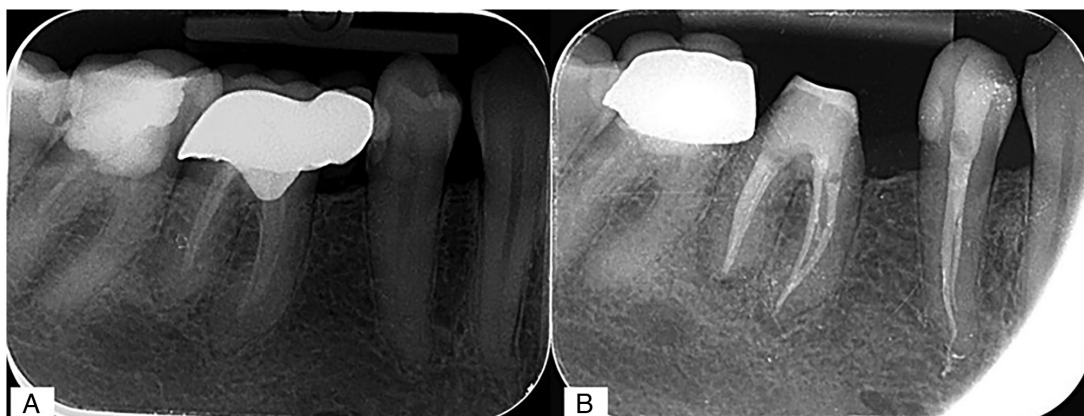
(A) Preoperative and (B) postoperative radiography of tooth 46 (lower right 1st molar) and tooth 44 (lower right 1st premolar) filled with Ah Plus Jet.
